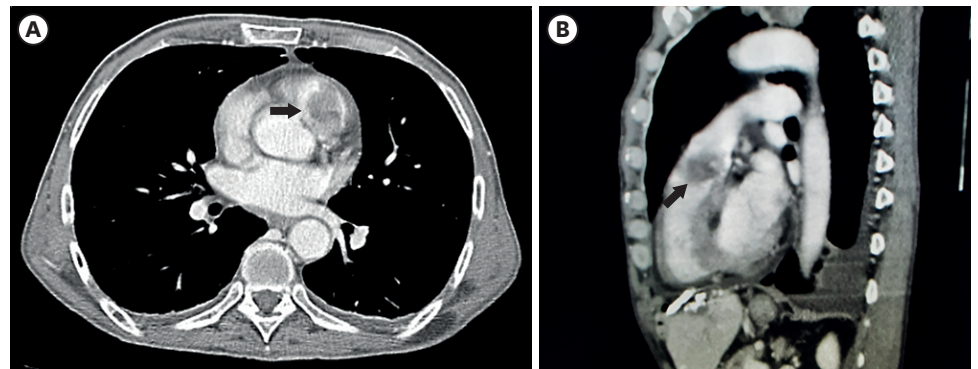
Chest CT angiography. The axial scans revealed a mass, likely at the level of the pulmonary valve (A); the sagittal scans confirmed the presence of the mass and better showed that it was attached to the ventricular side of the pulmonary valve (B). The finding was labeled as a thrombus. CT: computed tomography.
